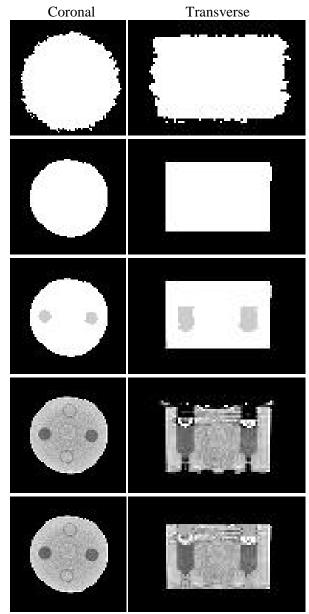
Maps used to attenuation correct SPECT data for quantification. (TOP to BOTTOM) 1) SPECT-based attenuation map and 2) CT-based attenuation maps with constant value of water, 3) segmented CT with constant values of water and methanol, 4) CT-based water attenuation coefficient linearly scaled from 36 to 140 keV, and 5) CT-based, segmented water and methanol attenuation coefficients linearly scaled from 36 to 140 keV.
